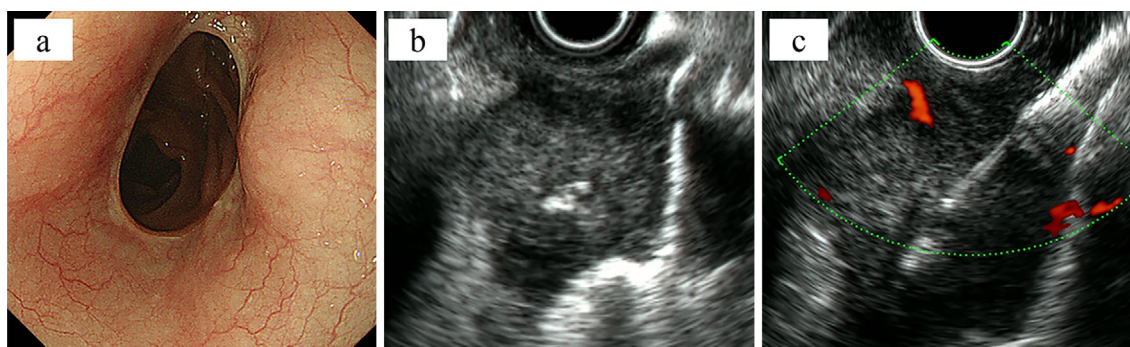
An extrinsic mass was found above the anastomosis by esophageal endoscopy (a), and the mass showed a hypoechoic area with calcification and cystic components by endoscopic ultrasound (b). Endoscopic ultrasound-guided fine-needle aspiration was performed for the mass in order to obtain a definitive diagnosis (c).
